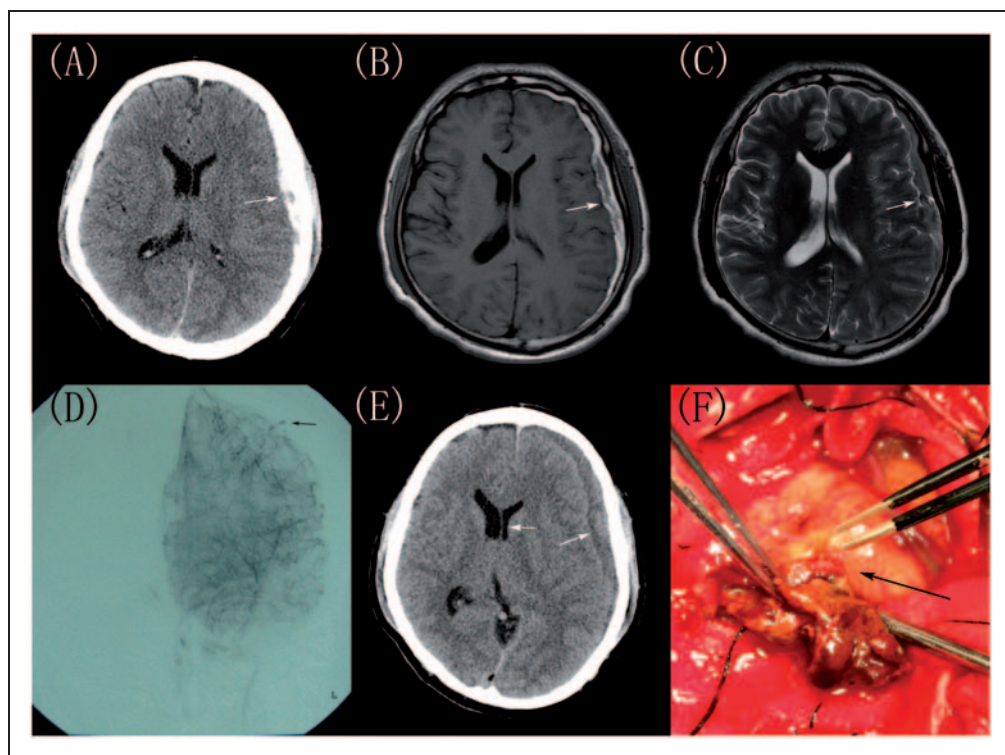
Brain images from a 43-year-old man presenting with a history of headache for 8 days. (A) Axial noncontrast computed topography (CT) scan showing a lunar hyperdense lesion in the left fronto-temporo-parietal region with no evidence of subarachnoid haemorrhage (white arrow); (B) T₁-weighted magnetic resonance image (MRI) revealing the haematoma as high intensity with isointense components (white arrow); (C) T₂-weighted MRI revealing the haematoma as low intensity with high intensity components (white arrow); (D) Angiogram of the left middle cerebral artery (MCA) revealing a small aneurysm located in the distal region of the MCA (black arrow); (E) Axial noncontrast CT scan showing mixed-density haematoma in the left fronto-temporo-parietal region with midline shift (white arrows); (F) Intraoperative view, confirming a small MCA aneurysm embedded in the subdural haematoma (black arrow). The colour version of this figure is available at: <http://imr.sagepub.com>.
